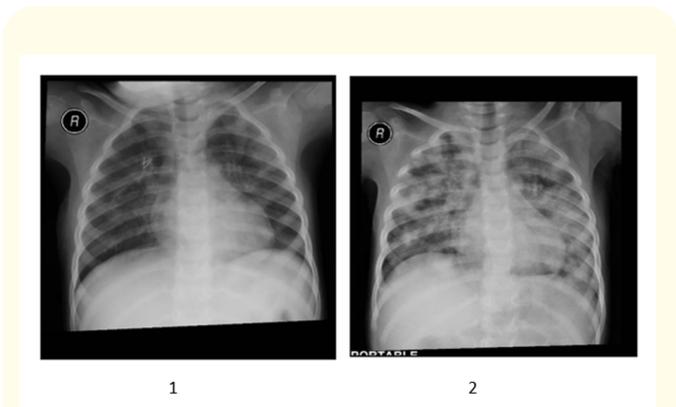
Posterioranterior chest radiography revealing acute phase of pulmonary infiltrations of idiopathic pulmonary Hemorrhage.
